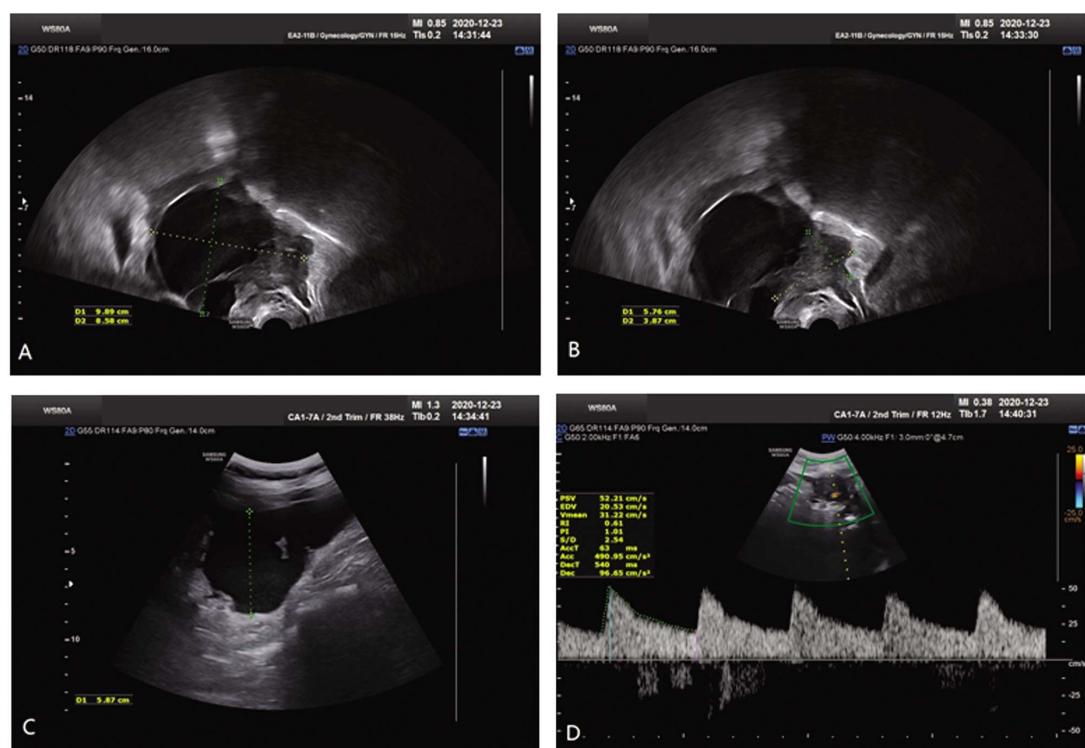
The patient, 57 years old, came to the hospital for examination due to abdominal distension for more than two months. Ultrasound showed a mass of 9.72 cm × 8.69 cm × 8.59 cm in the right posterior part of the uterus (Fig.1 A), which was the uneven hypoechoic area in the anechoic area, 5.77 cm × 3.54 cm (Fig.1 B), free fluid can be seen in the abdominal cavity on both sides (Fig.1 C), CDFI: stellate blood flow signal can be seen in the parenchyma, RI 0.61 (Fig.1 D).
